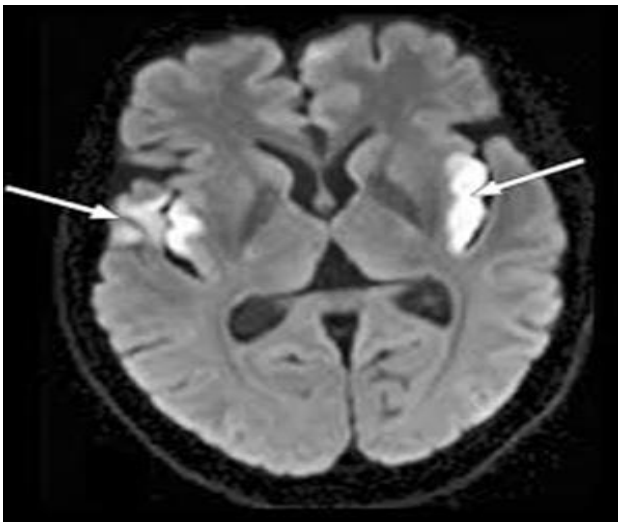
MRI brain T1W showing hyperintensities suggestive of old and new perisylvian infarcts.
